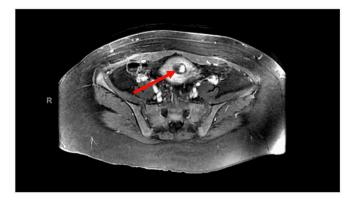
Axial MRI with contrast of pelvis showing 1.4×1.5 cm enhancing structure involving the uterine fundus consistent with uterine artery pseudoaneurysm.
